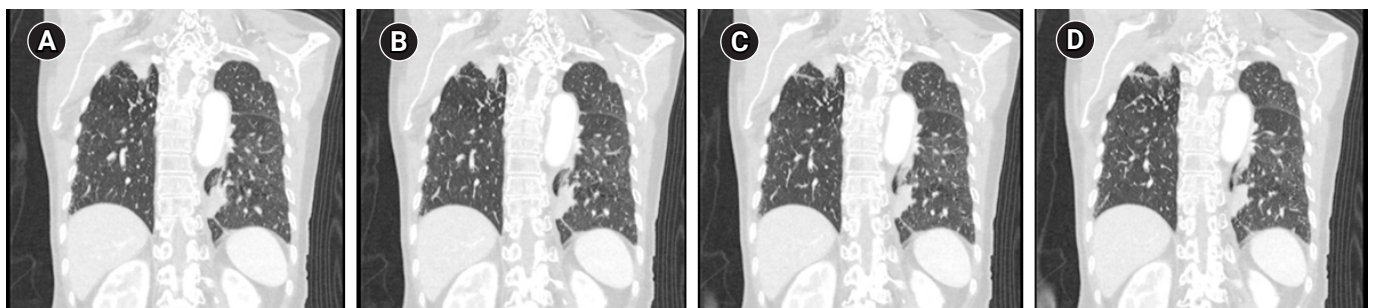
(A-D) Chest computed tomography showing focal mass like consolidation in left lower lobe posterior basal segment medial aspect.
